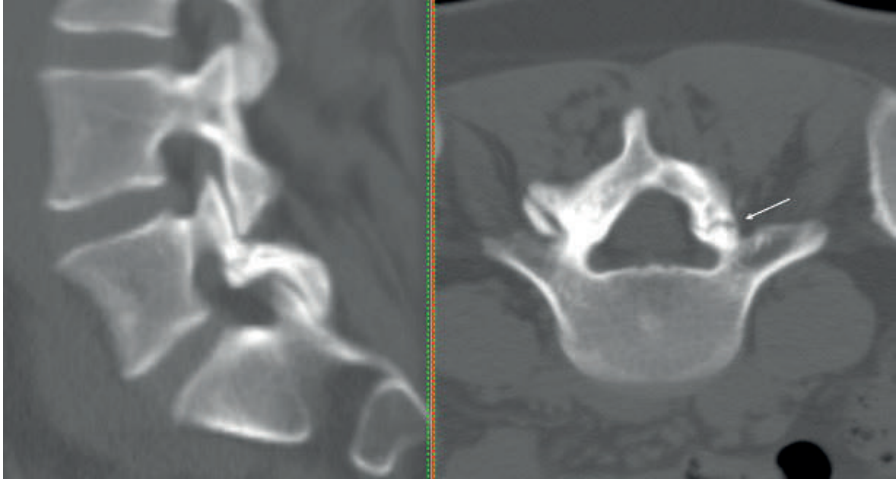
Unilateral pars interarticularis defect demonstrated on CT. Sagittal and axial computed tomography images of the lumbar spine demonstrating a unilateral defect in the pars interarticularis at the L5 level (arrow). The sagittal reconstruction shows cortical discontinuity of the pars region, while the axial section confirms unilateral involvement of the posterior element, consistent with unilateral isthmic spondylolysis.
